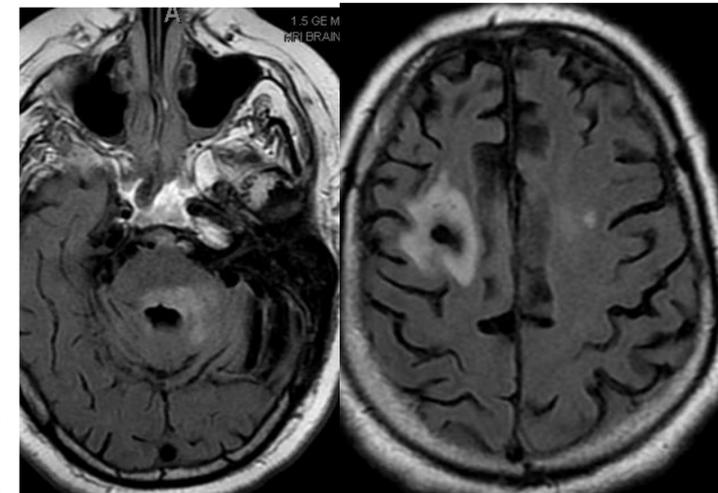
Brain MRI consistent with rhomboencephalitis
